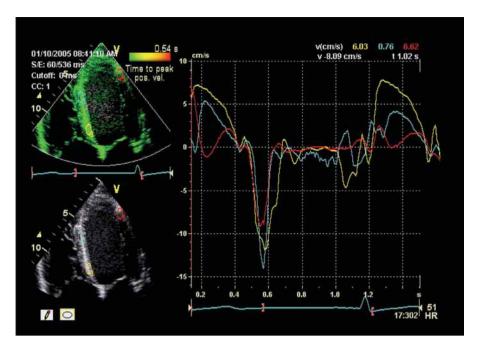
Doppler strain imaging. Doppler strain imaging showing normal synchronous tissue Doppler tracings of three interrogated myocardial segments are shown.
